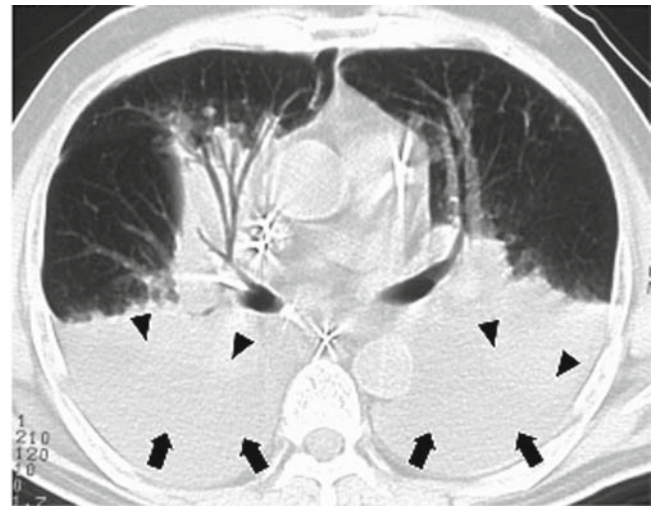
Chest CT scan on the second day in the ICU showed bilateral compression atelectasis (*black arrowheads*) and pleural effusions (*black arrows*)
